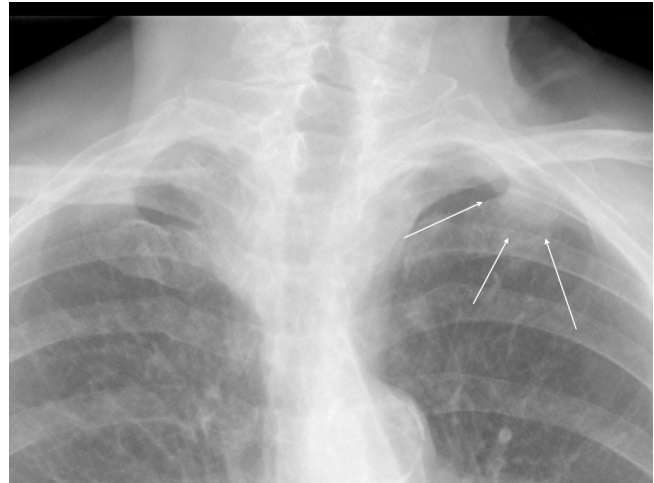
Subtle left apical mass on chest radiograph (arrows).
